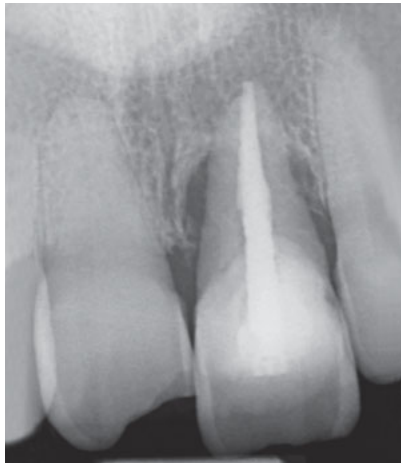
Radiograph showing mesial and distal vertical periodontal defects at tooth 21.
